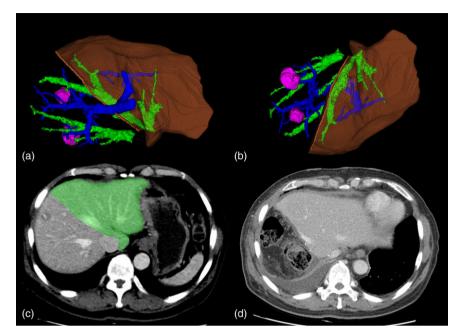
(a–c) Virtual resection of liver using Dr Liver. The transection line of the virtual liver resection followed the middle hepatic vein. The middle hepatic vein was excluded from the virtual resection area. (d) Follow-up computed tomography at postoperative day 7, used to recheck the Banatomical right hemi-hepatectomy following the middle hepatic vein. The real resection line was similar to the virtual resection line
